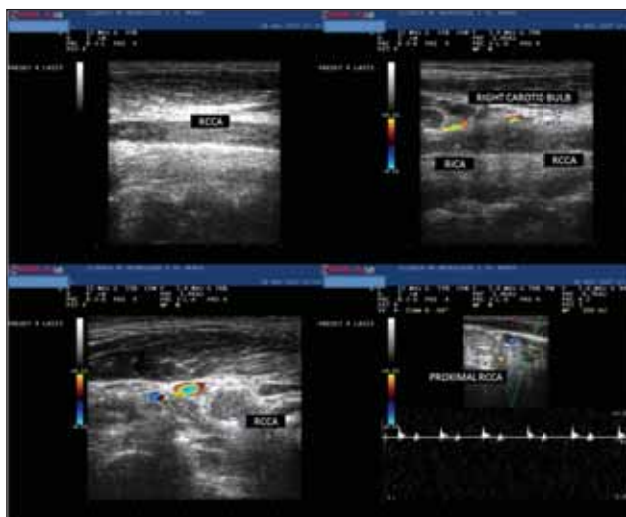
Carotid duplex ultrasonography. Complete thrombotic occlusion of the right common and internal carotid artery.
